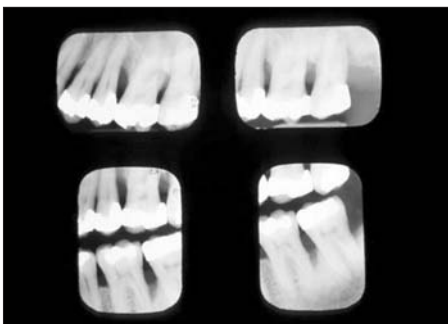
Radiograph reveals poor prognosis for teeth Nos. 13 and 15 with guarded prognosis on tooth No. 14.
